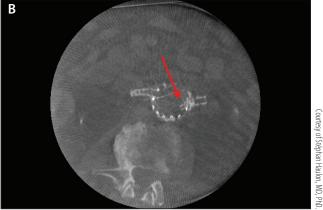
The superior mesenteric artery branch showing 3D patency and integrity of the stent (A). CBCT shows a kink in the left renal stent graft, which is subsequently treated before completion of the FEVAR procedure (B).
